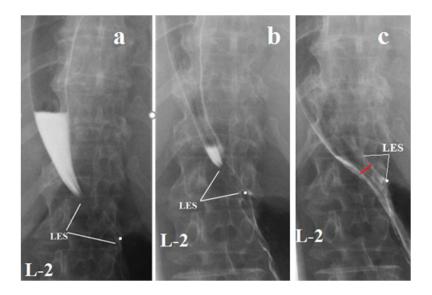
Consecutive radiographs after upright barium intake. The L-1 height is 2.2 cm. (a) The true length of the narrowing between the esophagus and the stomach is 3.1 cm. (c) With full opening of the LES its length became 2 times shorter - 1.6 cm. However, the upper border of the LES remained at the same level. There was a shortening of the LES due to the opening of its abdominal part.
